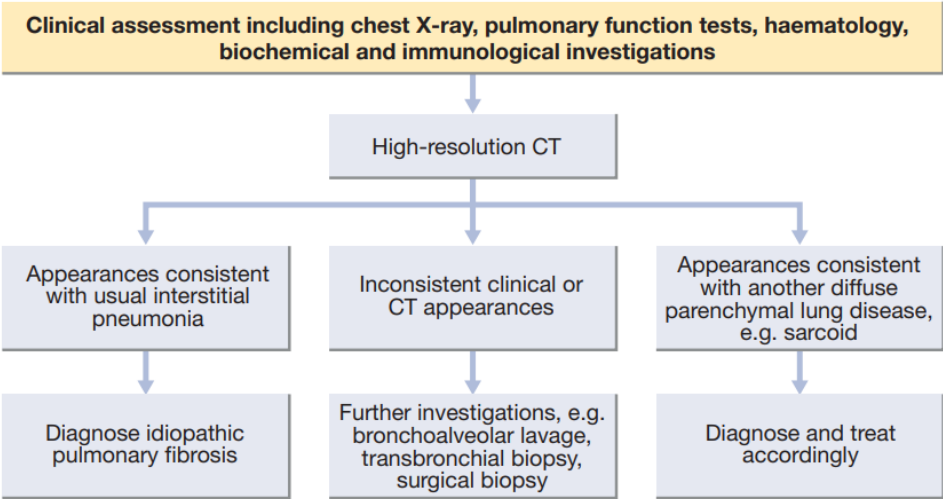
Algorithm for the investigation of patients with interstitial lung disease following initial clinical and chest X-ray examination.
